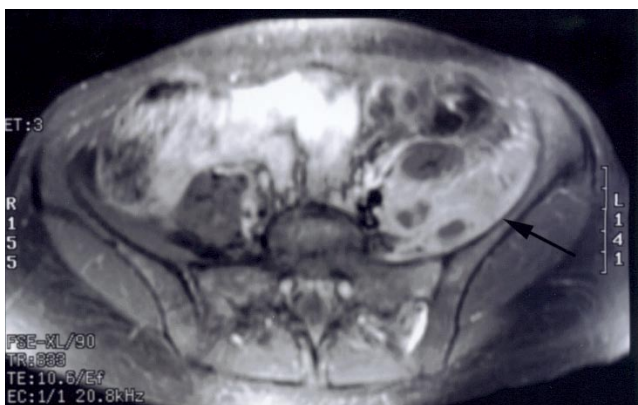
Magnetic resonance imaging (axial view) of pelvis showing multiloculated, iliopsoas abscess (arrow).
